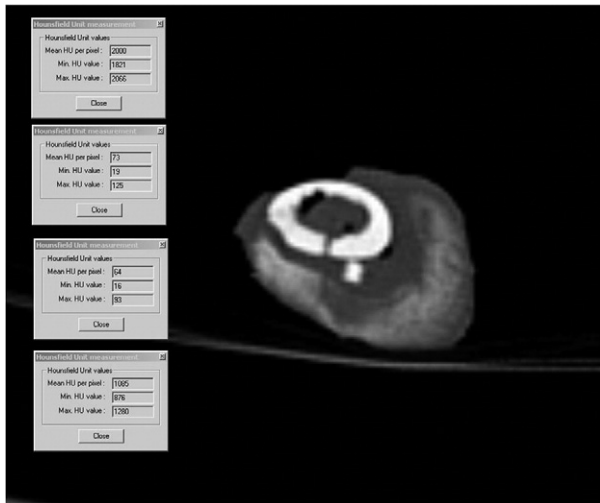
Computed tomographic image of contraction area.
